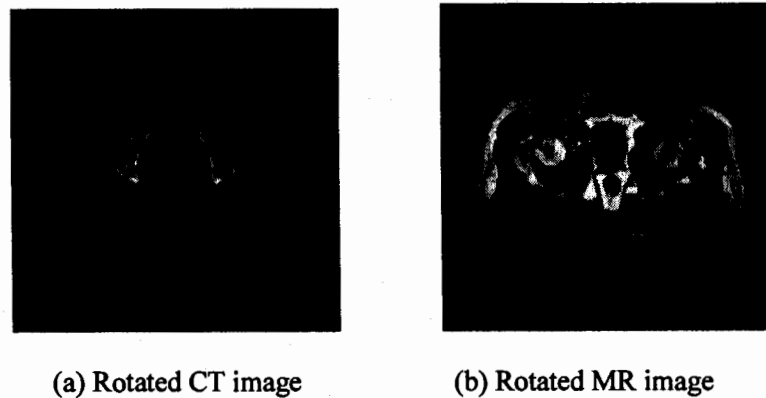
Rotated CT and MR Images of Pelvis by Proposed Method
